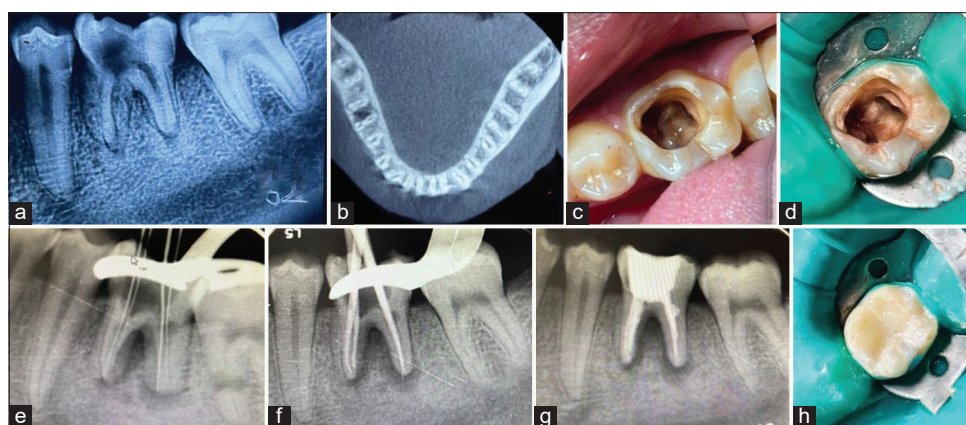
(a) Pre-operative radiograph; (b) cone-beam computed tomography showing extra buccal root; (c) pre-operative clinical picture; (d) rubber dam isolation; (e) working length determination; (f) master cone radiograph; (g) obturation; (h) post endodontic restoration (case 2)
